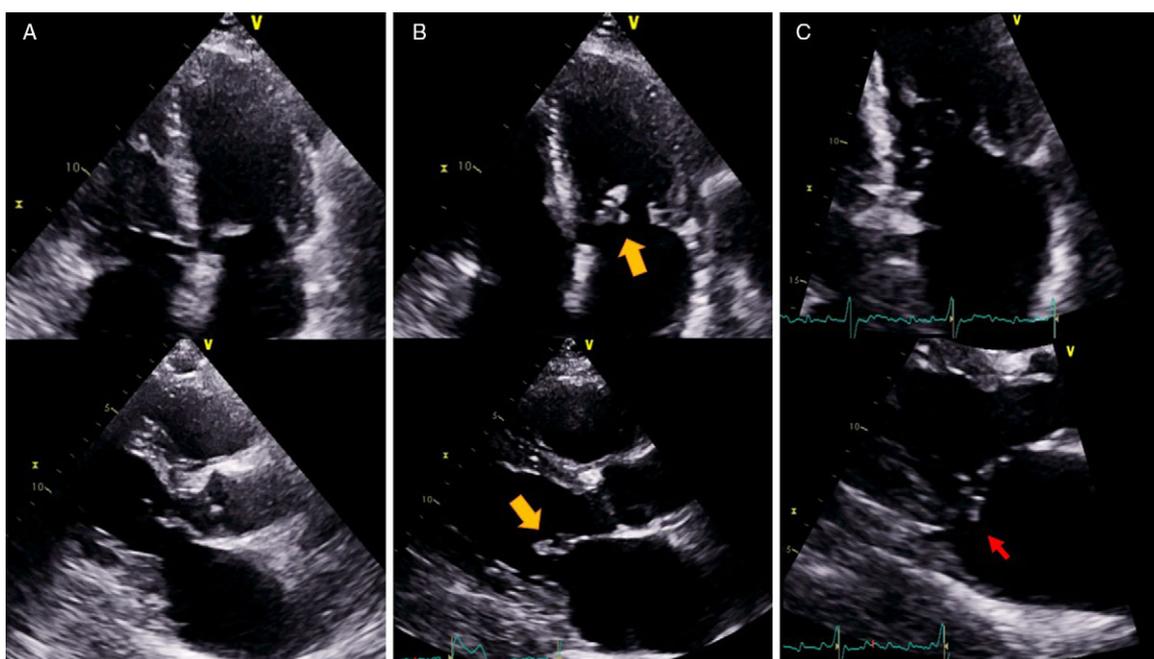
Four-chamber and parasternal long axis views of the mitral valve. Panel A shows the patient's baseline echocardiogram which was performed 2 months prior. The mitral valve was thickened secondary to degenerative changes. Panel B shows an independently mobile mass attached to the tip of the anterior mitral leaflet (thick arrow). The appearance was consistent with a vegetation. Panel C shows the resolution of the endocarditis after 4 weeks of antibiotic treatment, with no residual vegetation seen. The endocarditis further damaged the mitral valve, and the patient was left with a flail anterior mitral leaflet (narrow arrow).
